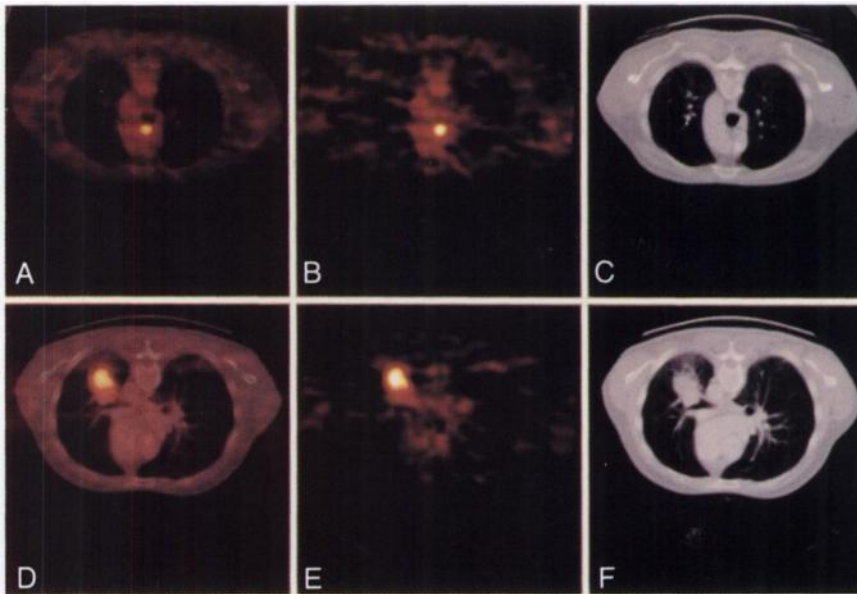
Two axial slices are shown. (A, D) CT scans. (B,E) PET scans and (C,F) are the merged images for the two slices, respectively.
